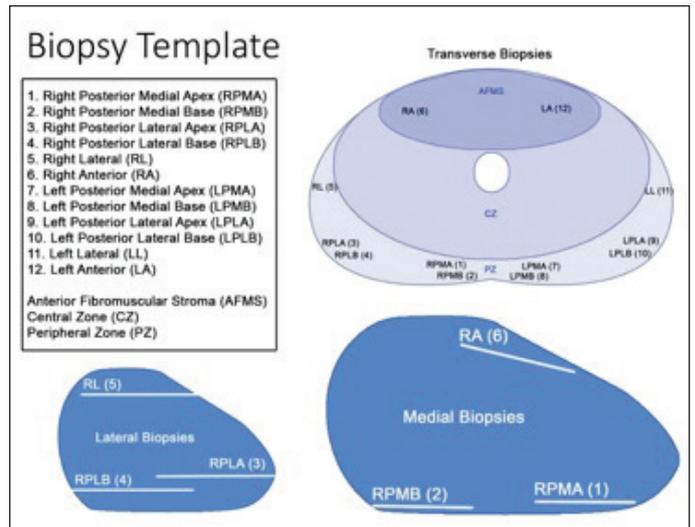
Transperineal biopsy template used in addition to any magnetic resonance imaging target lesions sampled.
